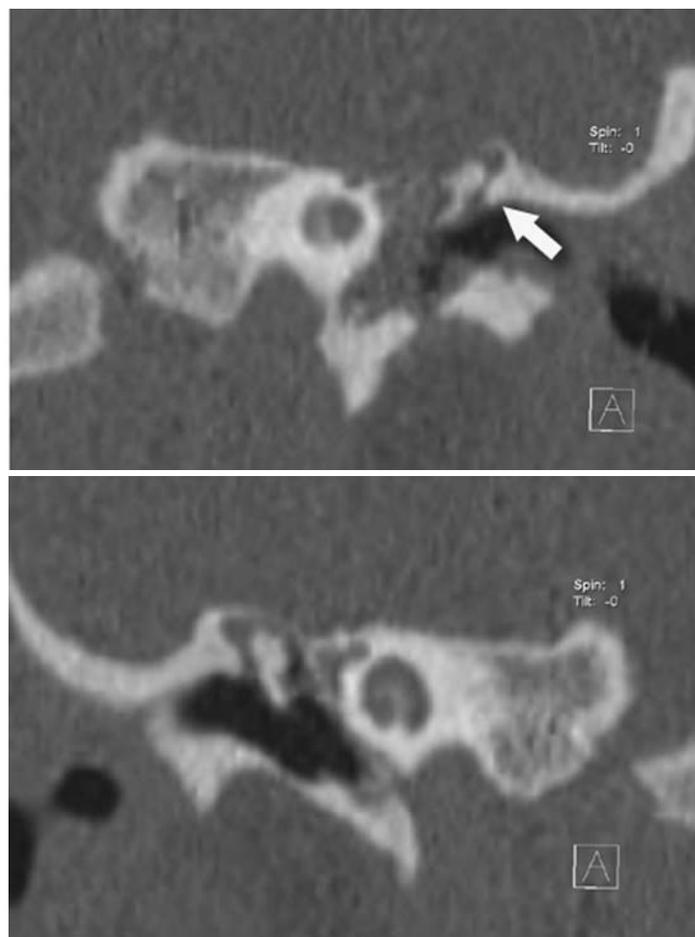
Coronal HRCT images of the scutum. The top scutum (white arrow) does not appear to be blunted when compared to the bottom scutum, which is known to be intact. The left middle ear space is entirely filled with a soft tissue lesion, whilst there is only soft tissue in the right epitympanum lateral and superior to the ossicles.
